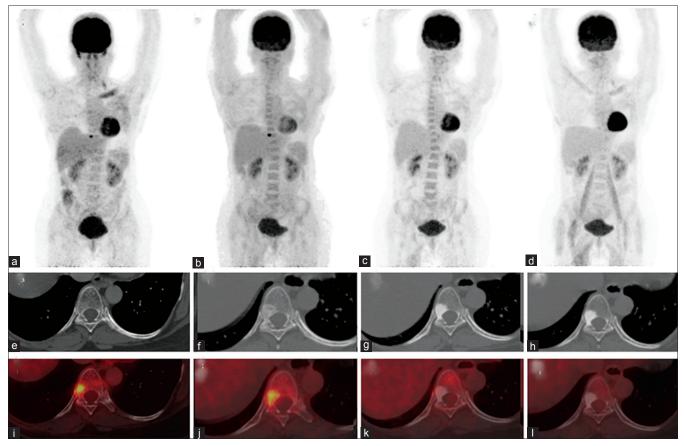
Serial maximum intensity projection images and the axial computed tomography (CT) and axial fused positron emission tomography (PET)-CT of the serial PET scans during the course of second line treatment of bilateral cancer breast are shown. Initial images (a, e, i-prechemotherapy; showing a focus of elevated fluorodeoxy glucose (FDG) uptake in a lytic lesion in the posterior body and right pedicle of the D9 vertebra. Follow-up scan (b, f, j-three cycles after chemotherapy) showed an increase in the FDG uptake (flare phenomenon) with sclerotic changes on CT; PET scan after six cycles of chemotherapy (c, g, k) and nine cycles of chemotherapy (d, h, l) show complete suppression of FDG uptake with dense sclerotic change in the involved vertebra
